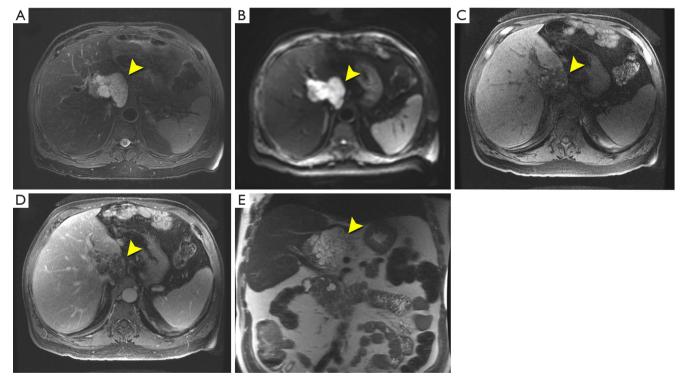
Representative images from the MRI study in Case 2. Axial T2-weighted (A), diffusion weighted (B), pre-contrast T1-weighted (C) and post-contrast portal venous phase T1-weighted (D) images. Note the multilobulated and multiseptated cystic lesion (yellow arrowheads) with (A,E) heterogeneously increased T2 signal, (B) restricted diffusion and (C,D) focal areas of peripheral enhancement on delayed imaging. Additionally, the mass is separate from the pancreas (E).
